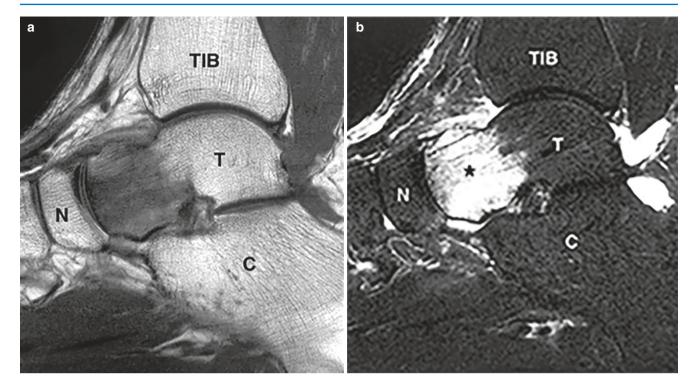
Marrow Edema on MRI. Sagittal images of the ankle show marrow edema (*) which is (a) dark on T1-weighted image and (b) bright on STIR images. This marrow edema pattern is nonspecific and is similar to the marrow changes in osteomyelitis. However, this patient
